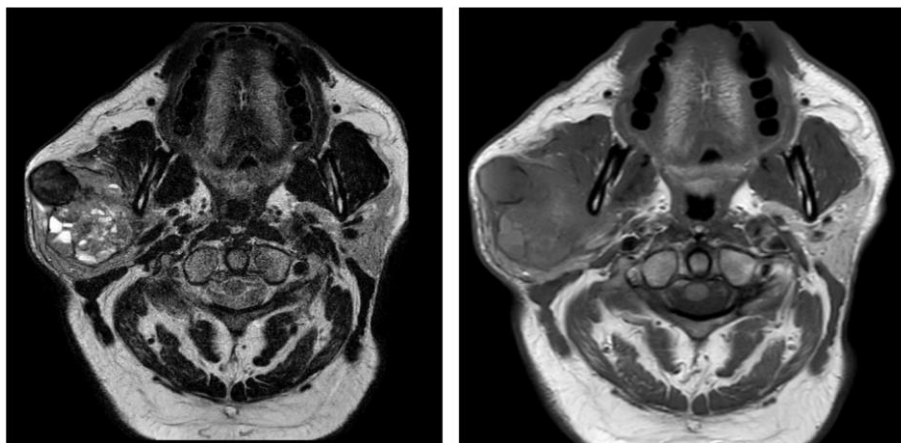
MRI axial view of the initial parotid gland tumor
